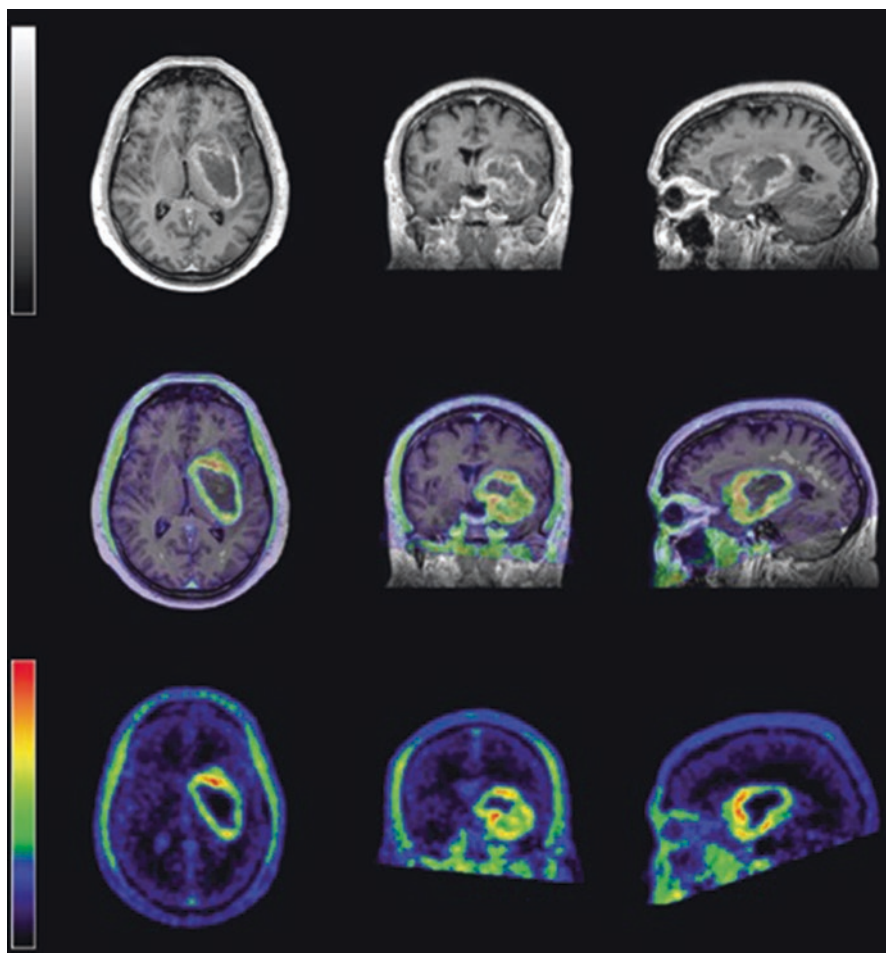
^{18}F -FAZA PET image (90–150 min smoothed with 4-mm Gaussian filter) overlaid on post-contrast T1-weighted MR image of glioblastoma patient. Note the different patterns of ^{18}F -FAZA brain uptake and gadolinium enhancement in the high grade tumour, particularly in the coronal (middle) and sagittal (right) views. *For courtesy of Dr. Natale Quartuccio and Dr. Marie-Claude Asselin [43]*
